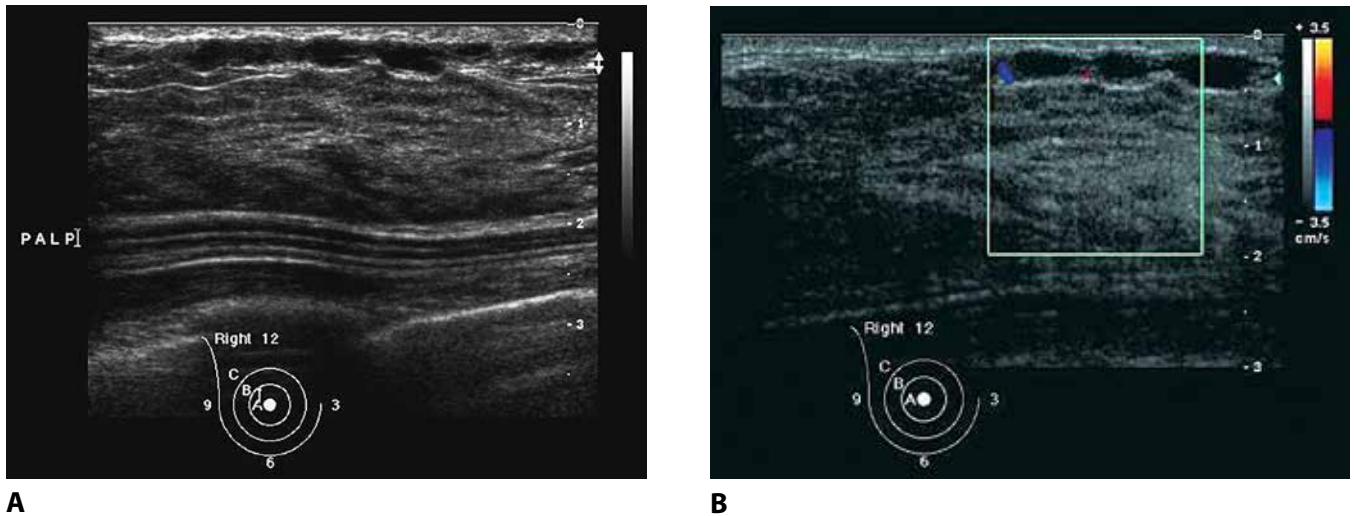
VASCULAR ABNORMALITIES: MONDOR DISEASE. This 23-year-old woman developed a painful cord in the right axillary tail. The cause was a thrombosed superficial lateral thoracic vein, seen in long axis just beneath the skin (*a*). Color Doppler image (*b*) showing essentially no vascular flow within the vein confirms the diagnosis. MONDOR DISEASE is self-limited and does not require anticoagulation.
